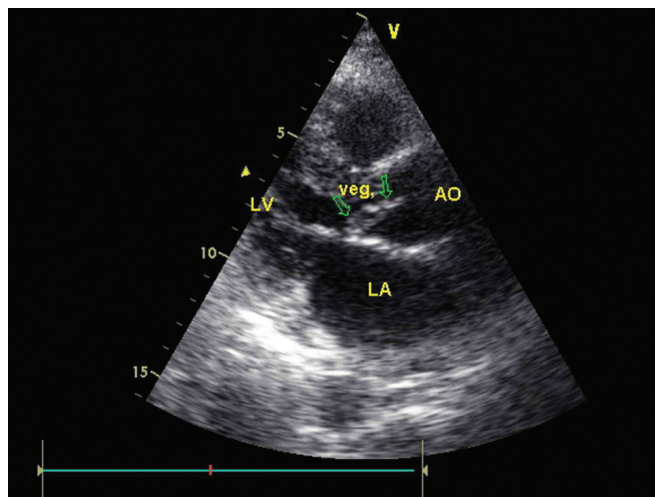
Preoperative echocardiographic view of vegetation in the right coronary cusp of the aortic valve. LA indicates left atrium; LV, left ventricle; AO, aorta; veg., vegetation.
